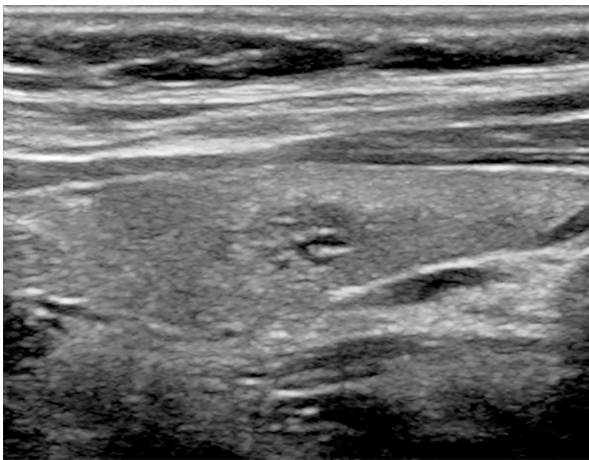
Nine-year-old male with hypothyroidism symptoms. Longitudinal sonographic images obtained with 7 MHz linear transducer. A thyroid nodule presenting with a similar appearance with intrathyroidal ectopic thymus tissue.
